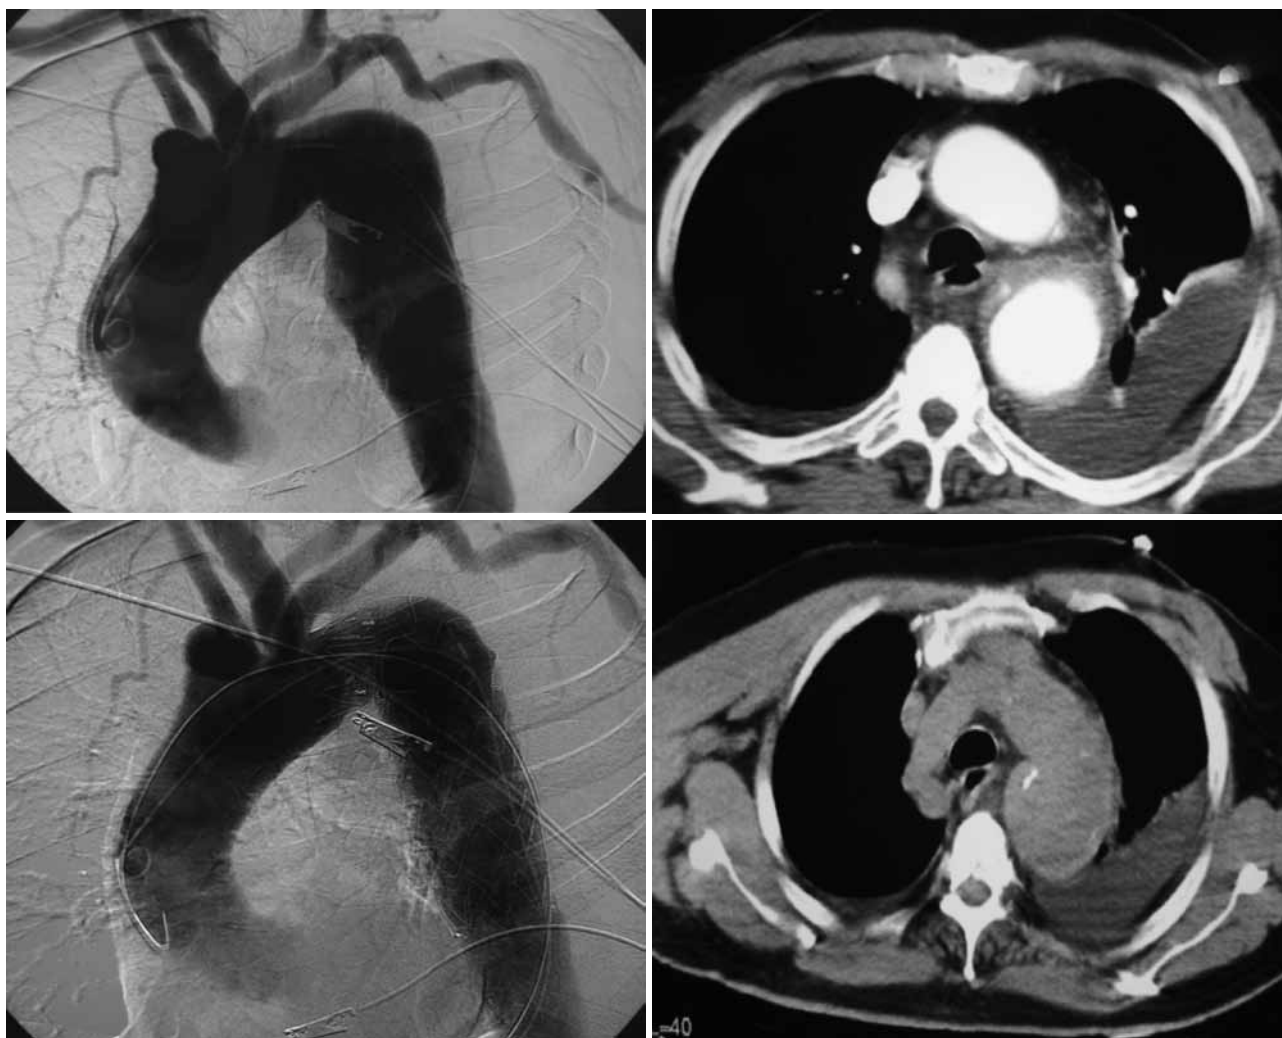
Type B intramural hematoma. CTA pre (two upper panels) and post (two lower panels) endovascular repair. CTA = computed tomography angiography.
